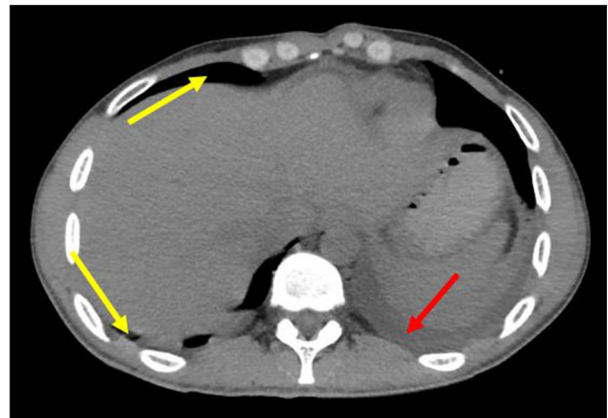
Abdominal CT scan before surgery showing free intraabdominal fluid on the posterior side (red arrow) and free extra-peritoneum air on anterior and posterior sides (yellow arrows) caused by abdominal perforation.
